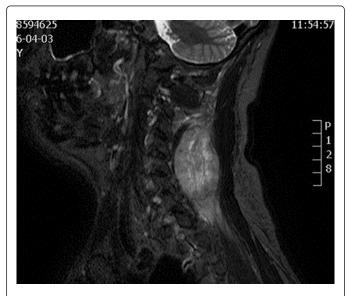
Sagittal image of cervical MRI before radiotherapy
